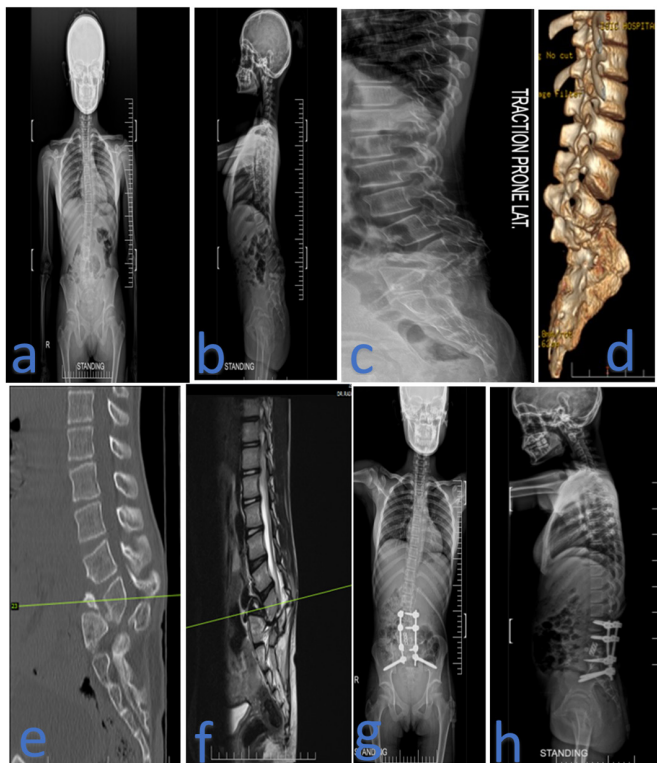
Imaging of a lumbosacral kyphosis patient with postoperative neurological deficit: preoperative radiographs (a–c), CT scans (d–e), MRI (f), and postoperative radiographs (g–h) showing spinal alignment and deformity correction.
